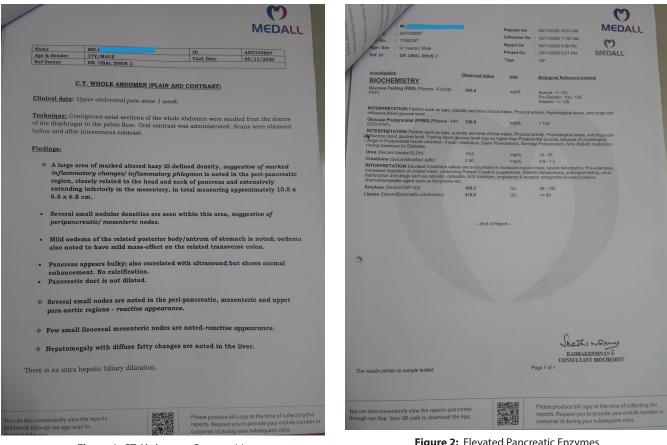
CT Abdomen - Pancreatitis
